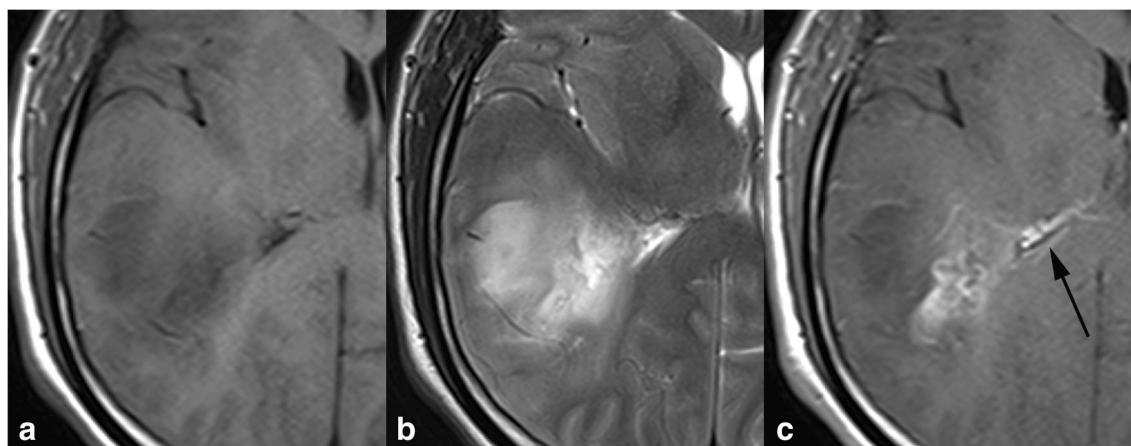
Brain magnetic resonance imaging revealed a primary gliosarcoma extending from the right temporal lobe to the lateral ventricle, with a heterogeneous but predominantly hypointense signal during T1-weighted imaging (a) and hyperintensity during T2-weighted
